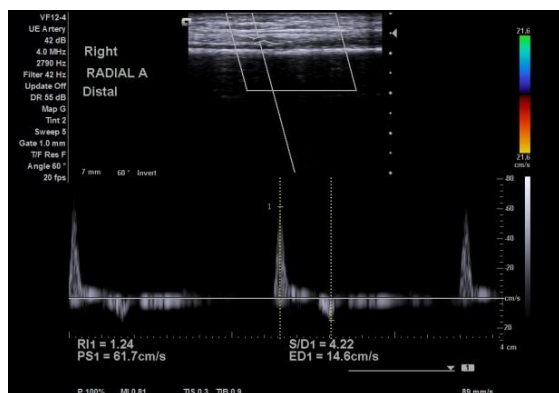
A. Right upper extremity ultrasonography showed a 1.09cm x 1.79cm dilatation in the right distal artery with a hyperechoic intraluminal density in the periphery. B. Doppler study showing the turbulent forward and backwards flow or “yin-yang sign” characteristic of a pseudoaneurysm with partial thrombosis. C. Increased peak systolic velocities with turbulent color flow in the right distal radial artery proximal to the pseudoaneurysm. D. The classic “to and fro” pattern characteristic of a pseudoaneurysm.
